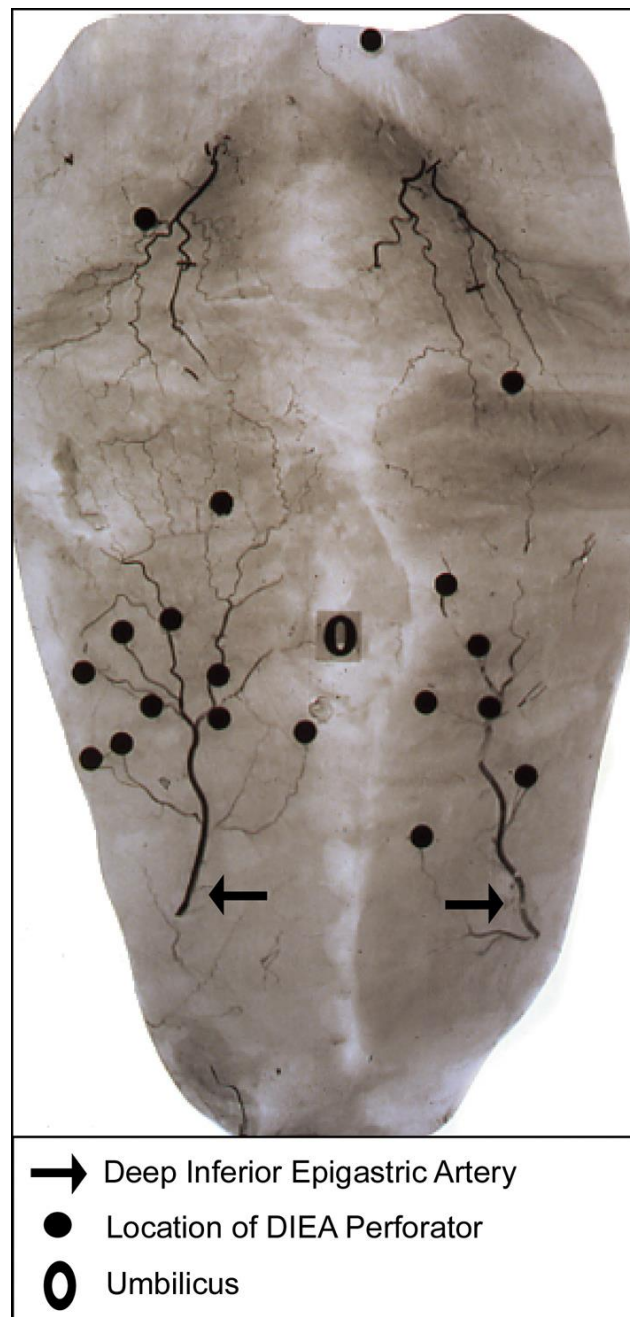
X-ray of the abdominal wall, demonstrating the course of the deep inferior epigastric artery (DIEA) and the location of its perforators (metallic beads) (29) (Reproduced with permission)
